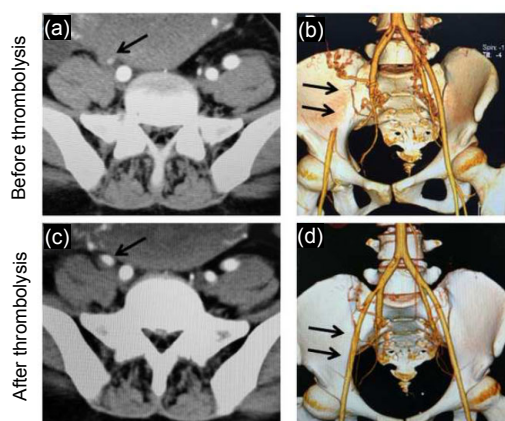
Imaging studies of iliac arteries using angiograph and 3D multi-detector computed tomography (MDCT) before and after thrombolysis
